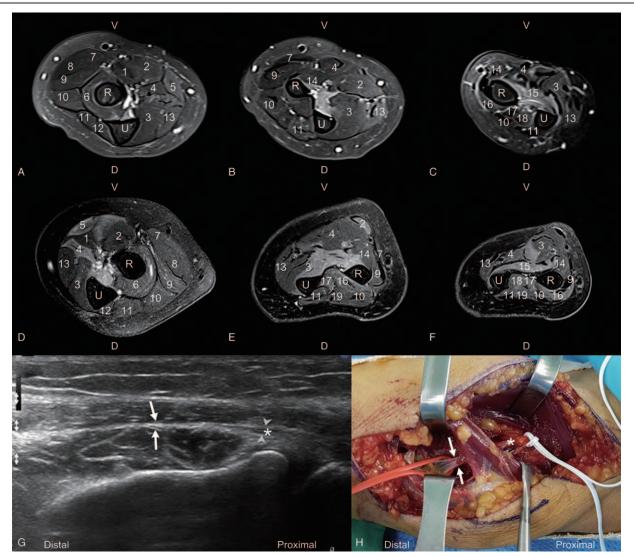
T2-weighted contrast-enhanced MRI of both forearms (A–F), preoperative ultrasonographic findings of the left posterior interosseous nerve (G), and intraoperative findings of the left posterior interosseous nerve (H). 1; Pronator teres (PT), 2; Flexor carpi radialis (FCR), 3; Flexor digitorum profundus (FDP), 4; Flexor digitorum sublimis (FDS), 5; Palmaris longus (PL), 6; Supinator (SP), 7; Brachioradialis (BR), 8; Extensor carpi radialis longus (ECR)), 9; Extensor carpi radialis brevis (ECRb), 10; Extensor digitorum communis (EDC), 11; Extensor carpi ulnaris (ECU), 12; Anconeus (ANC), 13; Flexor carpi ulnaris (FCU), 14; Flexor digitorum communis (EDC), 11; Extensor carpi ulnaris (ECU), 12; Anconeus (ANC), 13; Flexor carpi ulnaris (FCU), 14; Flexor digiti (FPL), 15; Pronator quadratus (PQ), 16; Abductor pollicis longus (APL), 17; Extensor indicis proprius (EIP), 18; Extensor pollicis longus (EPL), 19; Extensor digit minimi (EDM), V; Volar, D; Dorsal, R; Radius, U; Ulna. A–C, Right forearm; (D–F), left forearm. G, Preoperative ultrasonography of the left posterior interosseous nerve (PIN; arrowheads), Showing the constriction of the left PIN within the supinator muscle (arrows) and swelling of the nerve (*) just proximal to the muscle. H, Intraoperative findings of the left PIN, with constriction (arrows) within the muscle and swelling (*) proximal to the muscle.
